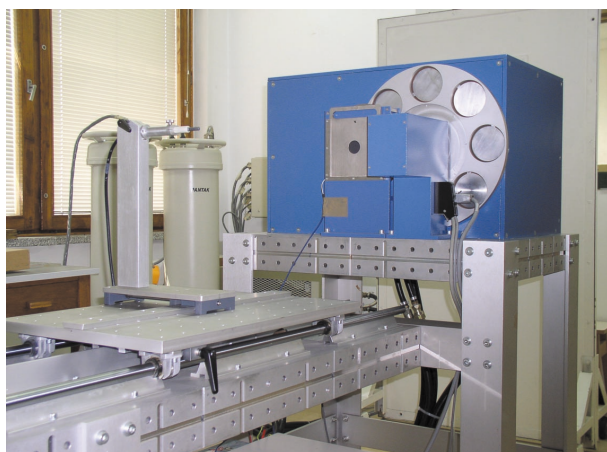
View on the installations in the RTG Lab. The measurement bench, rotational filter changer, and the chamber holders are seen in the forefront of the X-ray generator
